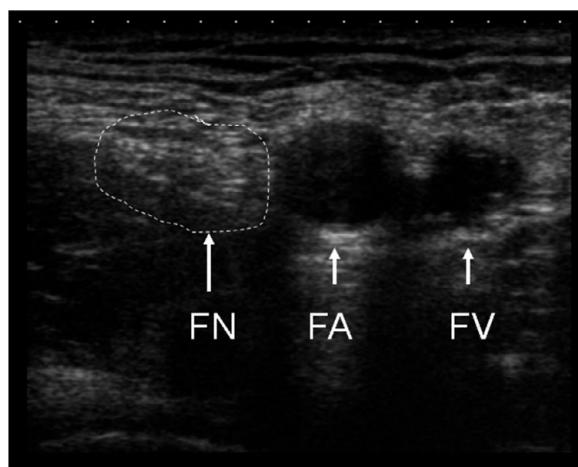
Cross-sectional anatomy of the femoral anatomy. FN, femoral nerve; FA, femoral artery; FV, femoral vein. Reproduced with permission from Arthurs G, Nicholls B (eds). 2016. *Ultrasound in Anesthesia, Critical Care, and Pain Management*. Cambridge, UK: Cambridge University Press
